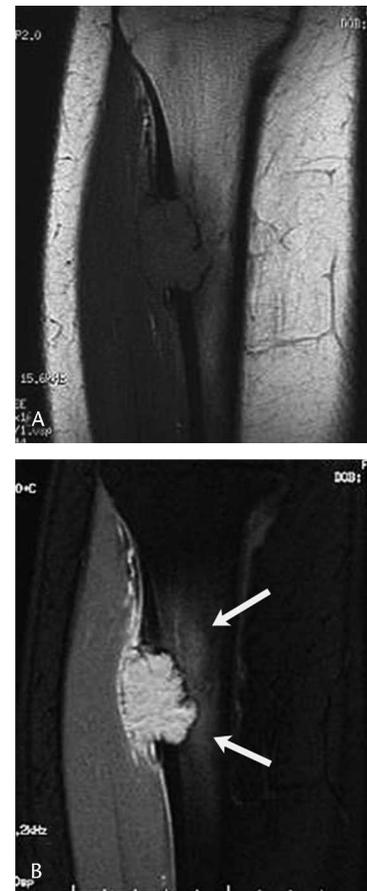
(A) A coronal T1-weighted MR image and (B) a coronal T2-weighted fat-saturated MR image demonstrate the lesion is predominantly hyperintense on T2-weighted images and low signal on T1-weighted images with a somewhat lobular configuration and suggestion of thin internal septa. There is a well-defined low signal intensity border medially; however, there is increased T2 signal within the adjacent bone marrow, suggestive of reactive edema (arrows). (C) An axial T1-weighted fat-saturated MR image after intravenous gadolinium administration shows relatively homogeneous enhancement of the lesion. Enhancement is also noted involving the periosteum along the lateral and anterior margin of the proximal tibia (arrowheads).
